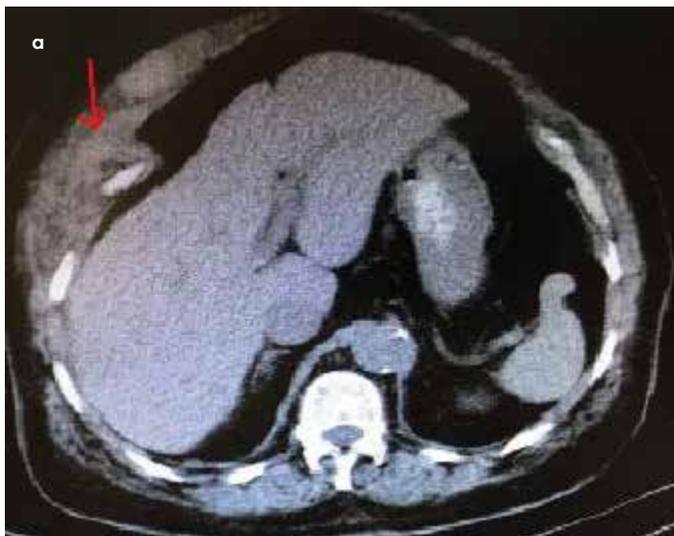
a, b. Computed tomography images of the patient
